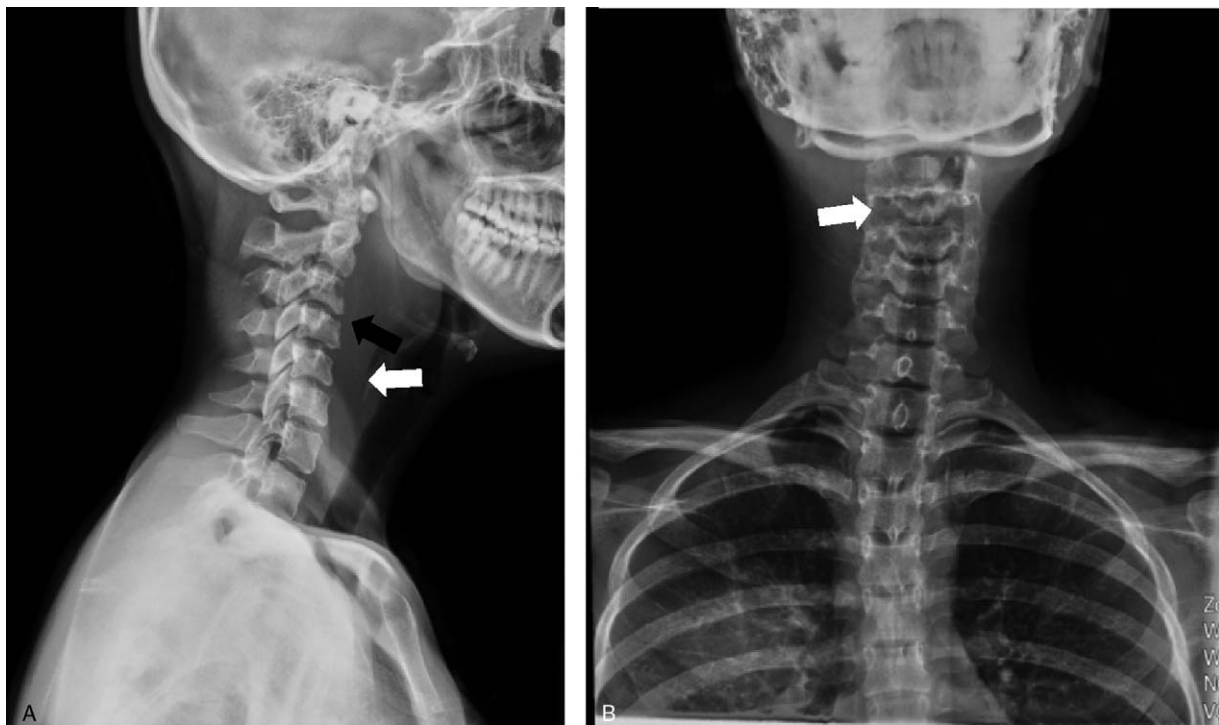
A, Cervical spine radiography, lateral view showed prevertebral soft tissue anterior to the C1 to C7 level (white arrow), focal destruction of the C3 vertebra (black arrow), and straightening of the cervical spine. B, Cervical spine radiography, anteroposterior view showed a mass displacing and indenting the adjacent airway (white arrow) and extrapulmonary opacity over the right upper lung field.
